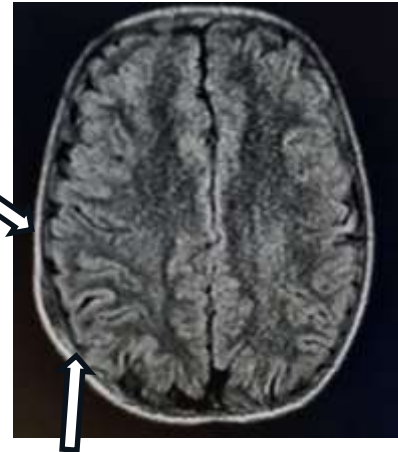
Cross-section of our patient's MRI showing a right parietal plane meningioma
